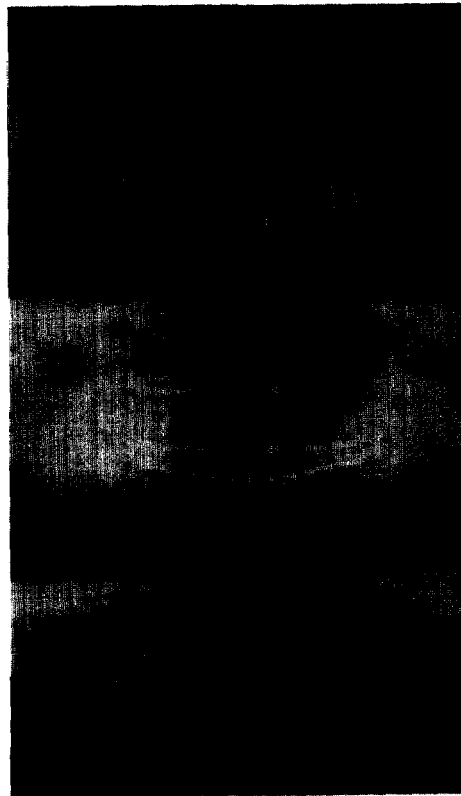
Preoperative and postoperative radiographs. Postoperative radiographs showing reduction of fracture by sagittal split and oblique subcondylar osteotomy with wires on both subcondylar area.
